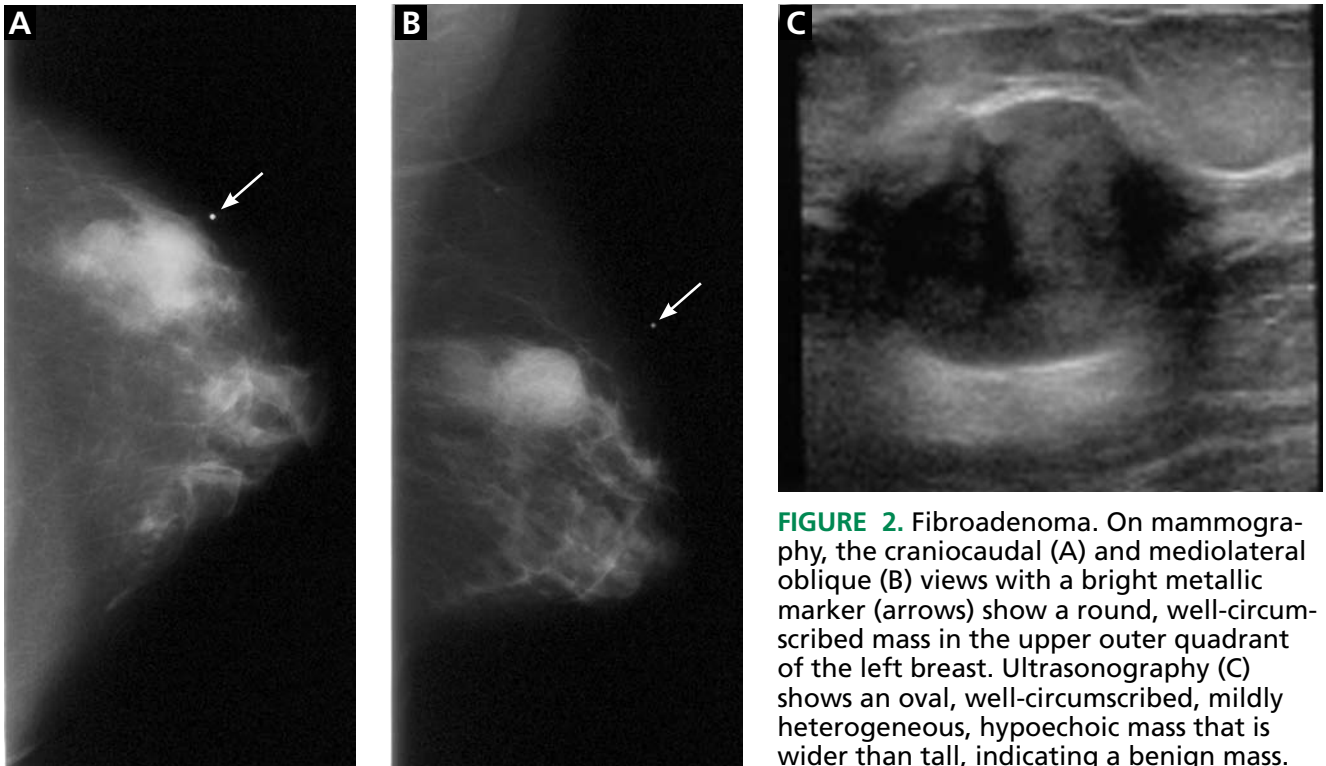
Fibroadenoma. On mammography, the craniocaudal (A) and mediolateral oblique (B) views with a bright metallic marker (arrows) show a round, well-circumscribed mass in the upper outer quadrant of the left breast. Ultrasonography (C) shows an oval, well-circumscribed, mildly heterogeneous, hypoechoic mass that is wider than tall, indicating a benign mass.
